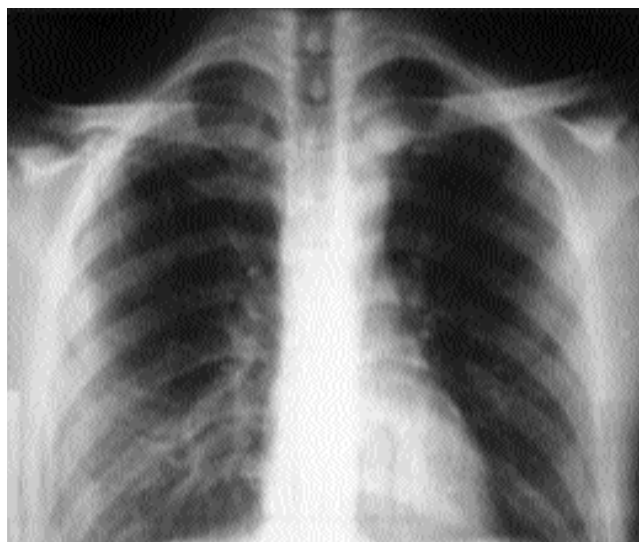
Plain film radiograph, demonstrating condensing osteitis as an area of increased density in inferior half the of the medial head of the left clavicle.
